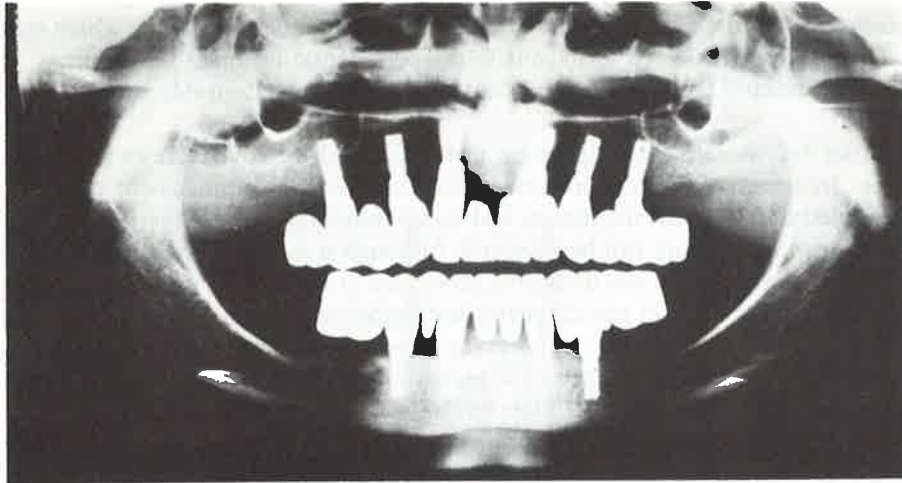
Radiograph of osseointegrated fixtures in an edentulous patient. Courtesy of Prof. P.-I. Brånemark, Institute for Applied Biotechnology, Gothenburg, Sweden.
